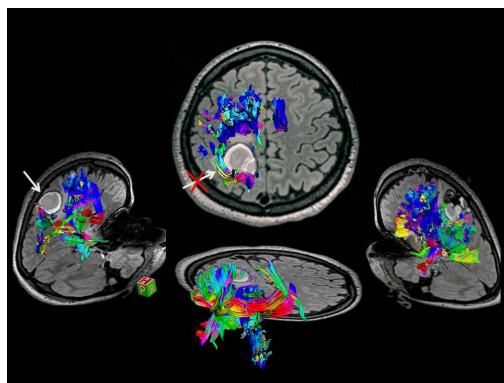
Intra-operative T₁ weighted MR image with 3D reconstruction diffusion tensor fiber tracking from a patient with cavernous angioma: Surgical trajectory was modified based on the relationship of motor and sensory fibers to the lesion.
